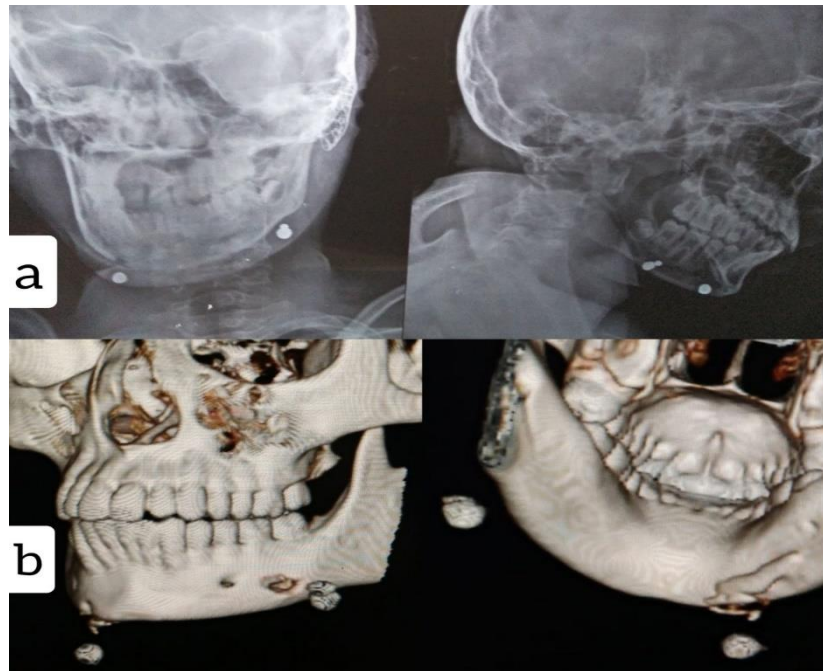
(a) PA mandible and lateral cephalic view radiographs, (b) 3DCT scan showing radio opaque foreign bodies.
